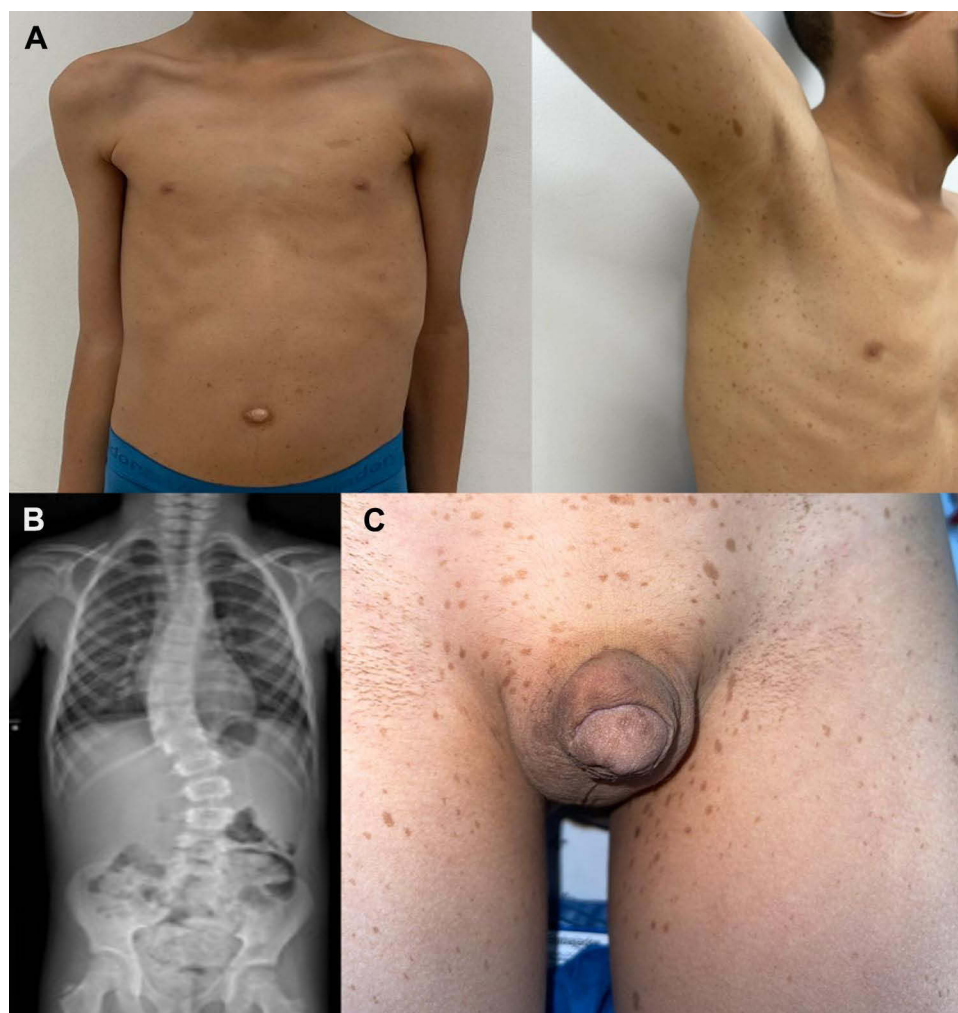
7-year-old patient. (A) Multiple cafe-au-lait macules in trunk and upper extremities, and axillary freckling. (B) Whole spine X-ray revealing thoracic scoliosis with right-sided curvature involving T7-T12, approximate angle of 42°, without spinal rotation. (C) Shawl and slightly hypoplastic scrotum and glandular hypospadias.
